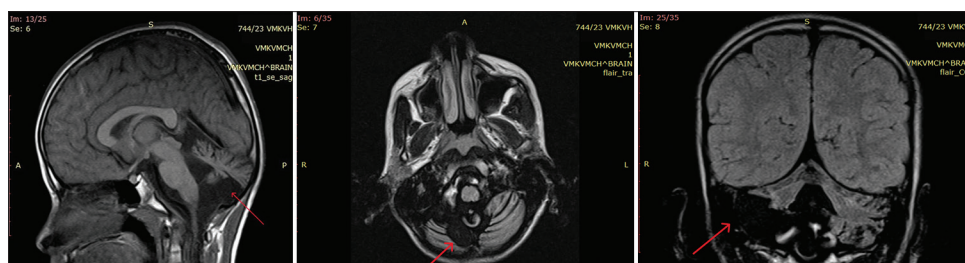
Sagittal, coronal, and axial sections of T1-weighted MRI of the brain of the case showing cerebellar vermal hypoplasia with global cerebellar cortex atrophy (red arrow)
